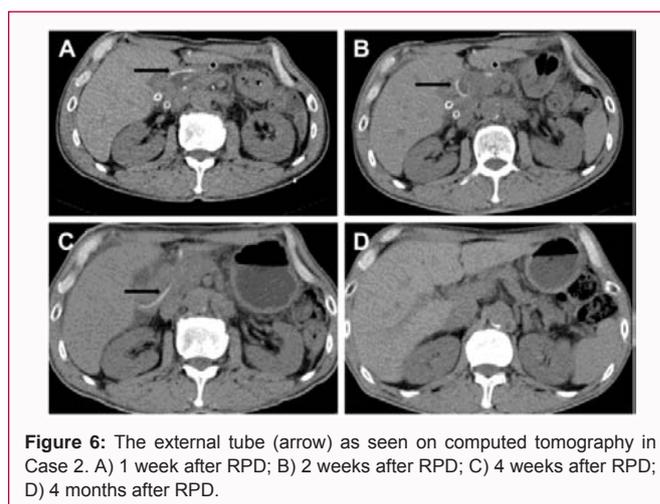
The external tube (arrow) as seen on computed tomography in Case 2. A) 1 week after RPD; B) 2 weeks after RPD; C) 4 weeks after RPD; D) 4 months after RPD.
